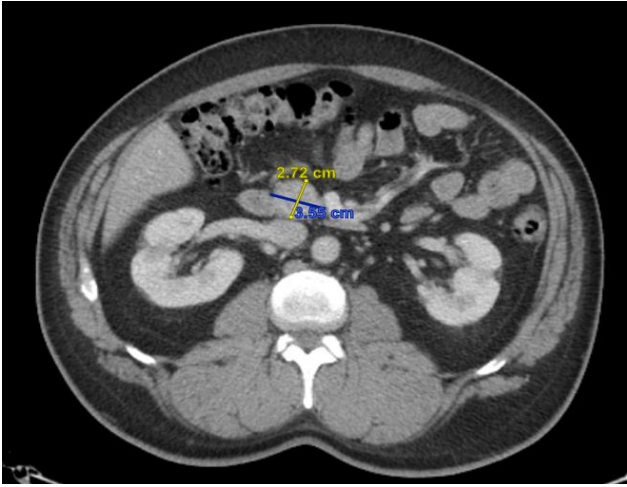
CT scan of the abdomen at presentation.
